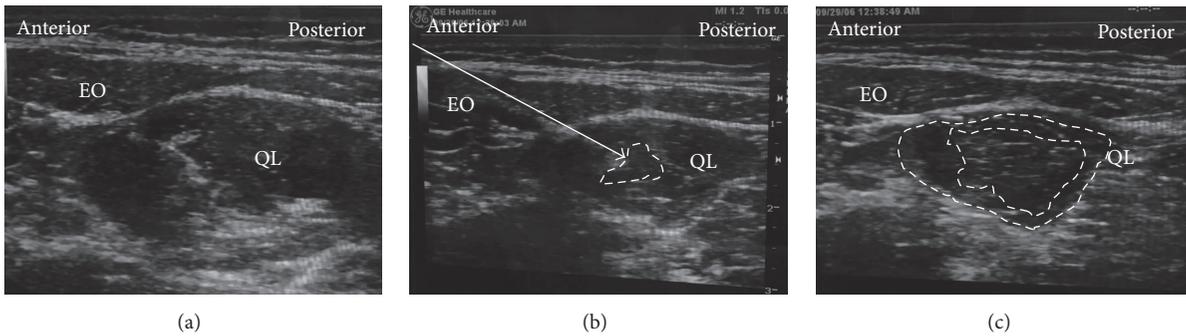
Ultrasound images of intramuscular QL. (a) Preinjection, (b) test injection, and (c) postinjection. EO: external oblique muscle, QL: quadratus lumborum, white arrow: needle trajectory, and white dotted line: spread of local anesthetic within (b) or in between (c).
